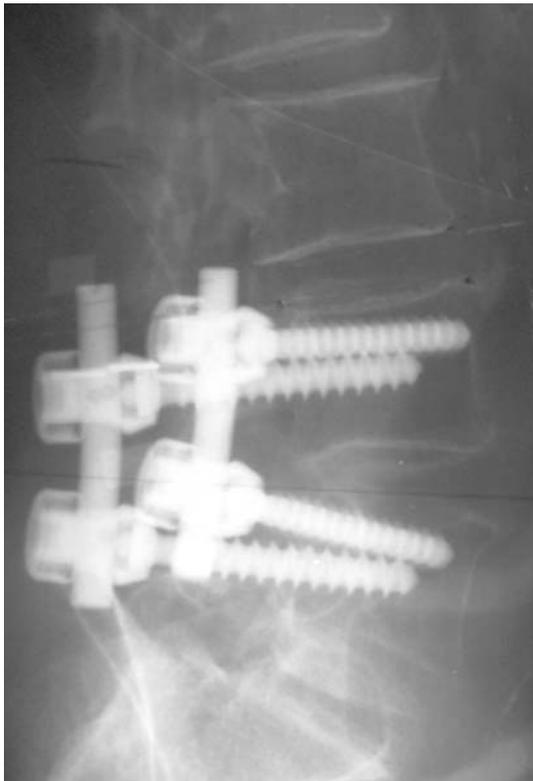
Lateral roentgenogram of the patient of Fig. 13, 57 months after L4/L5 laminectomy and discectomy plus instrumented fusion. At the segment L3/L4, a Wallis has been inserted (*arrow*). Note the normal height of the disc L3/L4
